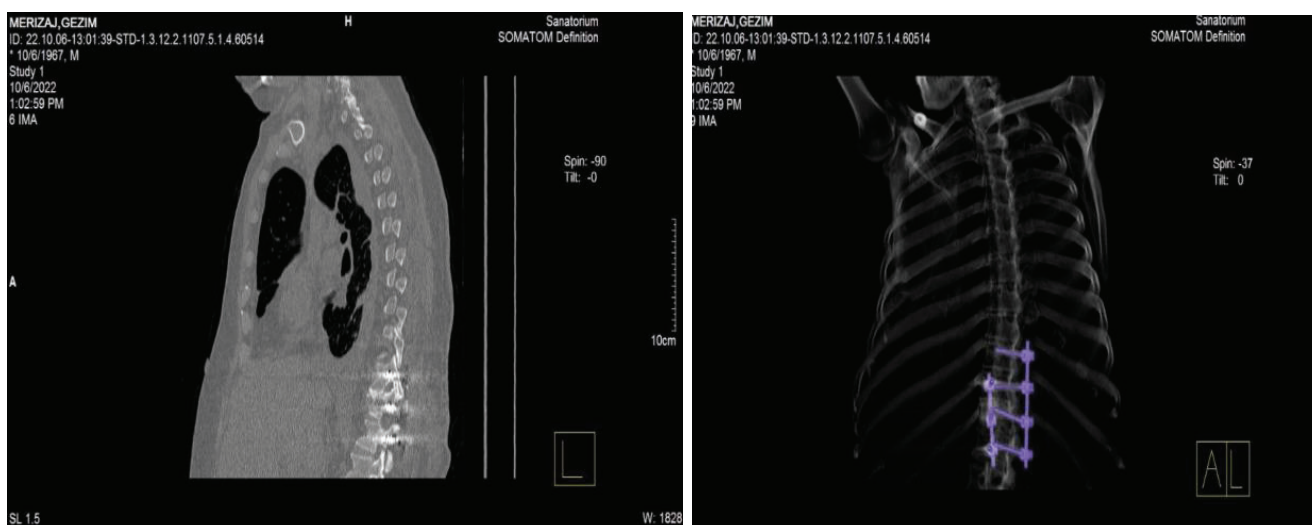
A thoraco-abdominal CT scan revealed an anterior fracture at the L1 vertebra and dislocation of the screw-rod.
